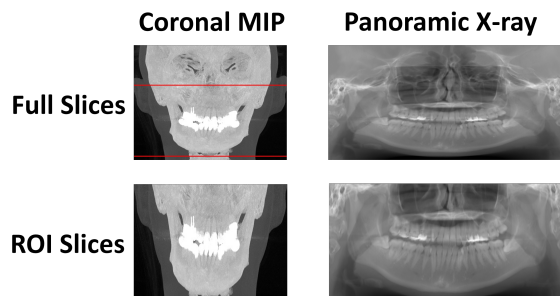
Result of slice extraction applied to a CT scan with a wide field of view.
